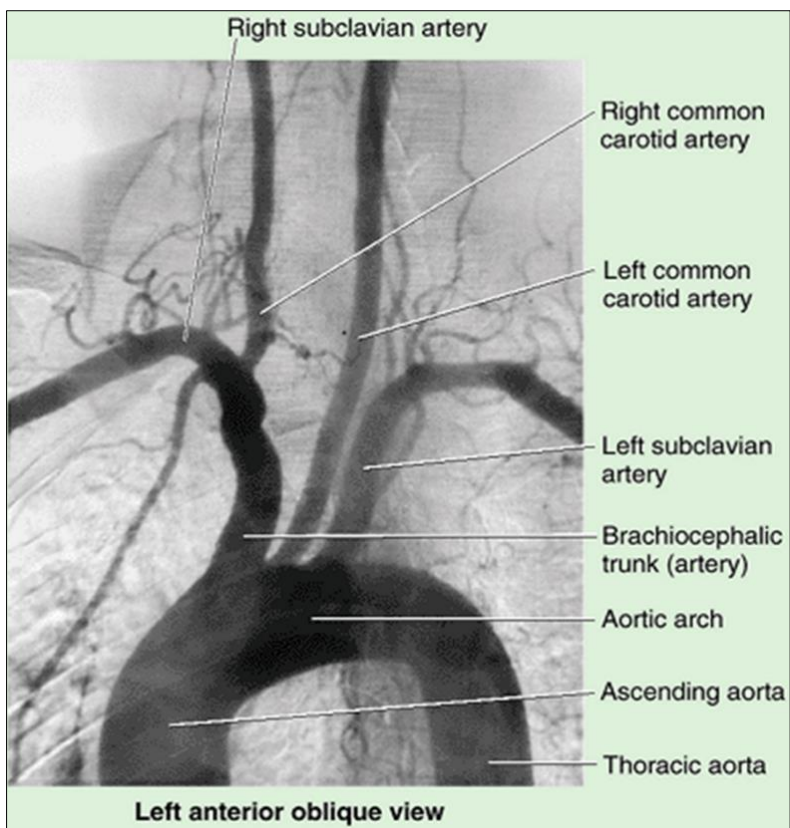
Contrast-enhanced Xray- Aortic arch Angiogram showing braches of the Arch
